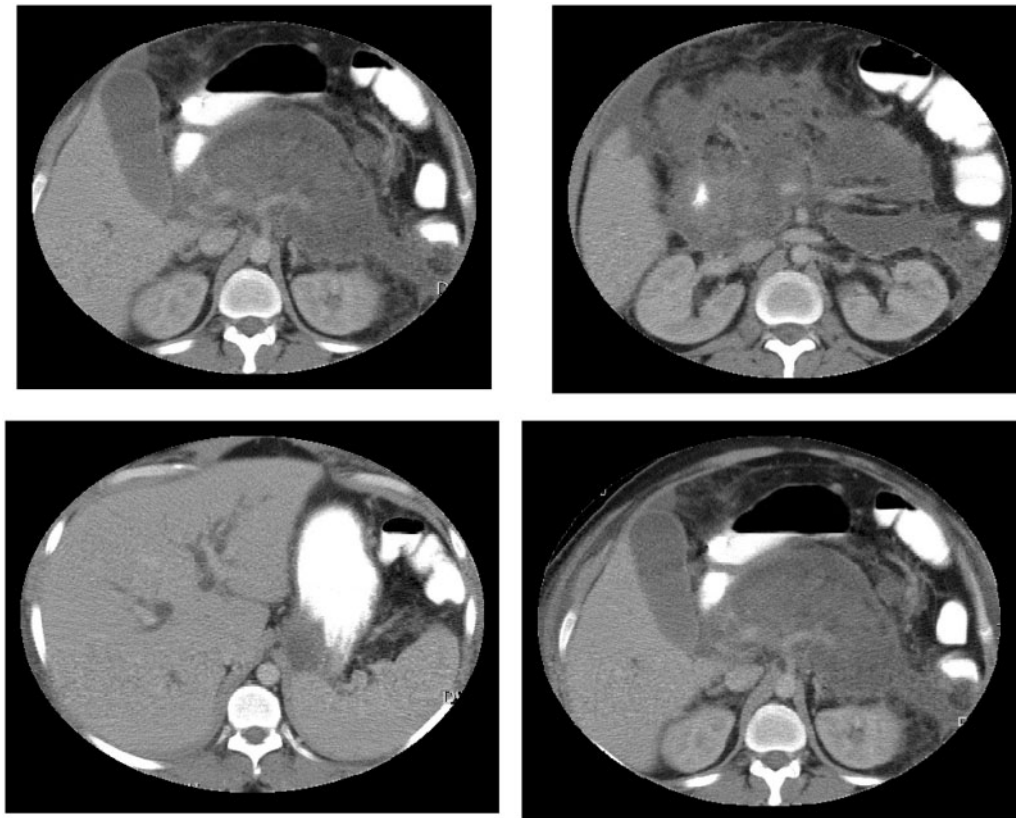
Abdominal CT scan with contrast showing oedematous pancreatic tissue with no obvious indication of a foreign body.
